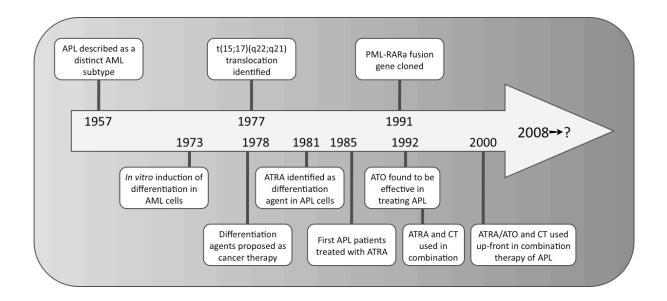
A timeline of differentiation therapy in AML. Selected milestones in the history of differention therapy of AML, and in particular its application in the treatment of APL. Indicated on top are some events associated with the characterization of APL. Shown below are milestones associated with differentiation therapy. Interestingly, identification of ATRA as a differentiation agent in APL preceeded the discovery of its receptor and its role in disease pathogenesis. ATO, arsenic trioxide; CT, chemotherapy.
